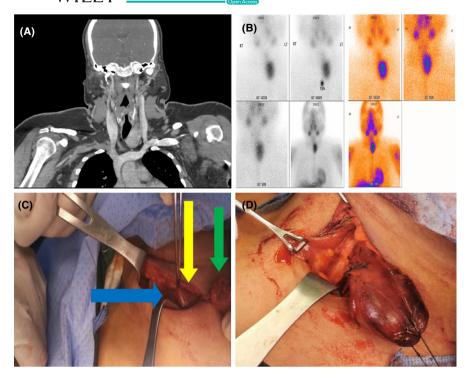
A, Coronal computed tomography scan of the neck showing absent right thyroid lobe. B, Nuclear scan localizing the left inferior parathyroid adenoma and confirming the right thyroid hemiagenesis. C, Intraoperative image showing absent right thyroid lobe (blue arrow), left thyroid lobe (yellow arrow), and the left inferior parathyroid adenoma (green arrow). D, Intraoperative image showing the left inferior parathyroid adenoma
